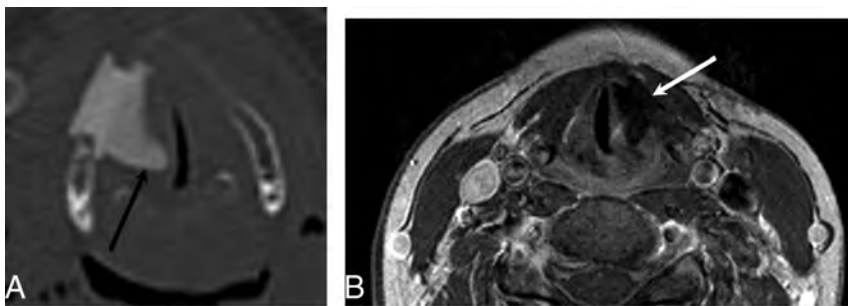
Montgomery Implant. A, Axial CT demonstrates a Montgomery Implant (*black arrow*) and appropriate medialization of the right vocal cord. Note the triangular configuration of the Montgomery Implant. B, Axial contrast-enhanced T1-weighted MR imaging in a different patient demonstrates triangular hypointensity adjacent to the left vocal fold, representing the Montgomery Implant (*white arrow*), with appropriate medialization of left vocal fold.
